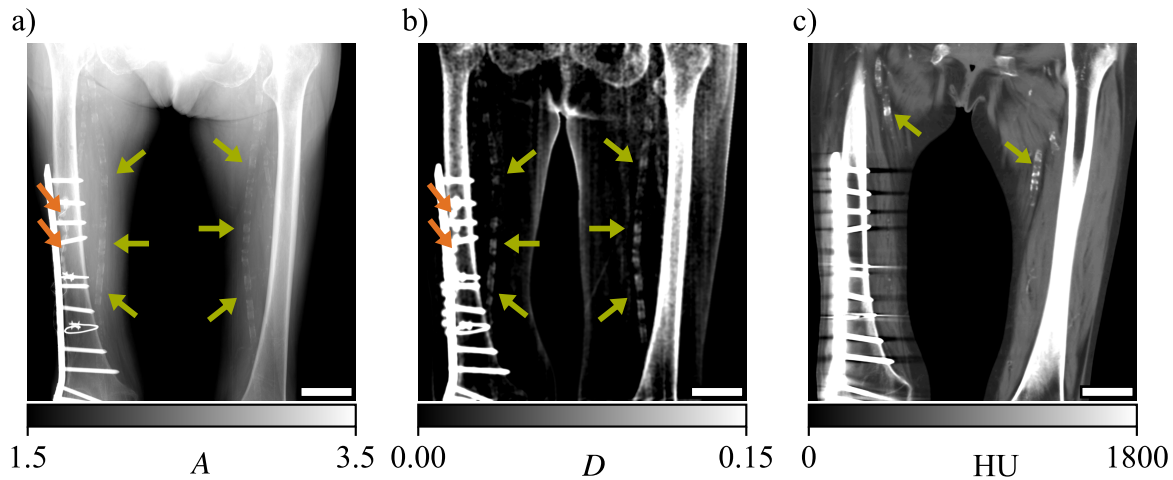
Attenuation (a), dark-field radiographs (b) and coronal CT slice of the upper legs. The scale bar in the lower right corner has the size $5\text{ cm} \times 1\text{ cm}$. In all three modalities, the metal screws and plate on the right femur, a fixation of an old fracture, are visible. The antibiotic bead chain, visible in both radiographic modalities, is indicated by the orange arrows. The green arrows indicate calcifications within the superficial femoral arteries.
